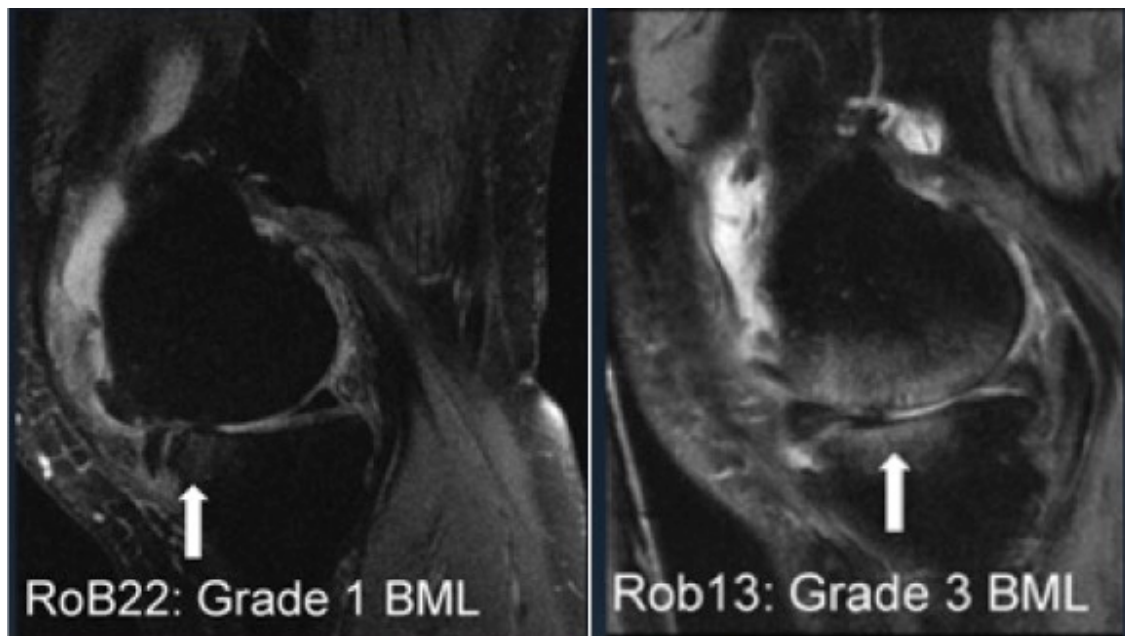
Sample MR image of OA patients with grade 1 BML (A) and grade 3 BML (B). Adapted from Seah 2012¹⁴⁰
